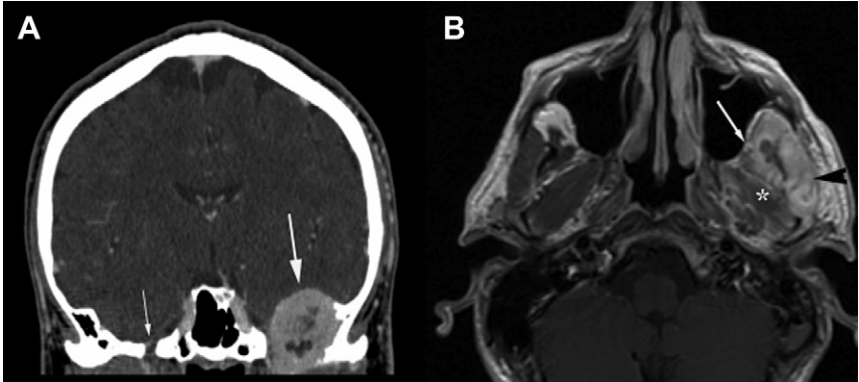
Early denervation. A 36-year-old man with a left skull base mass that proved to be a giant cell tumor. (A) coronal soft tissue CT image shows an enhancing mass involving the left foramen ovale (*large arrow in A*). The contralateral normal foramen ovale is indicated for comparison (*small white arrow*). (B) Follow up at 3 months, post contrast T1-weighted MR image shows enhancement of the masseter (*black arrowhead*) and temporalis (*white asterisk*).
